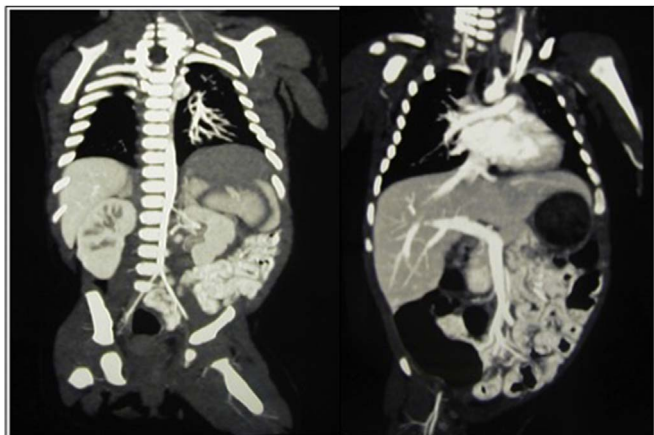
CT evaluation showing increased venous blood flow through the superior mesenteric and portal veins.
